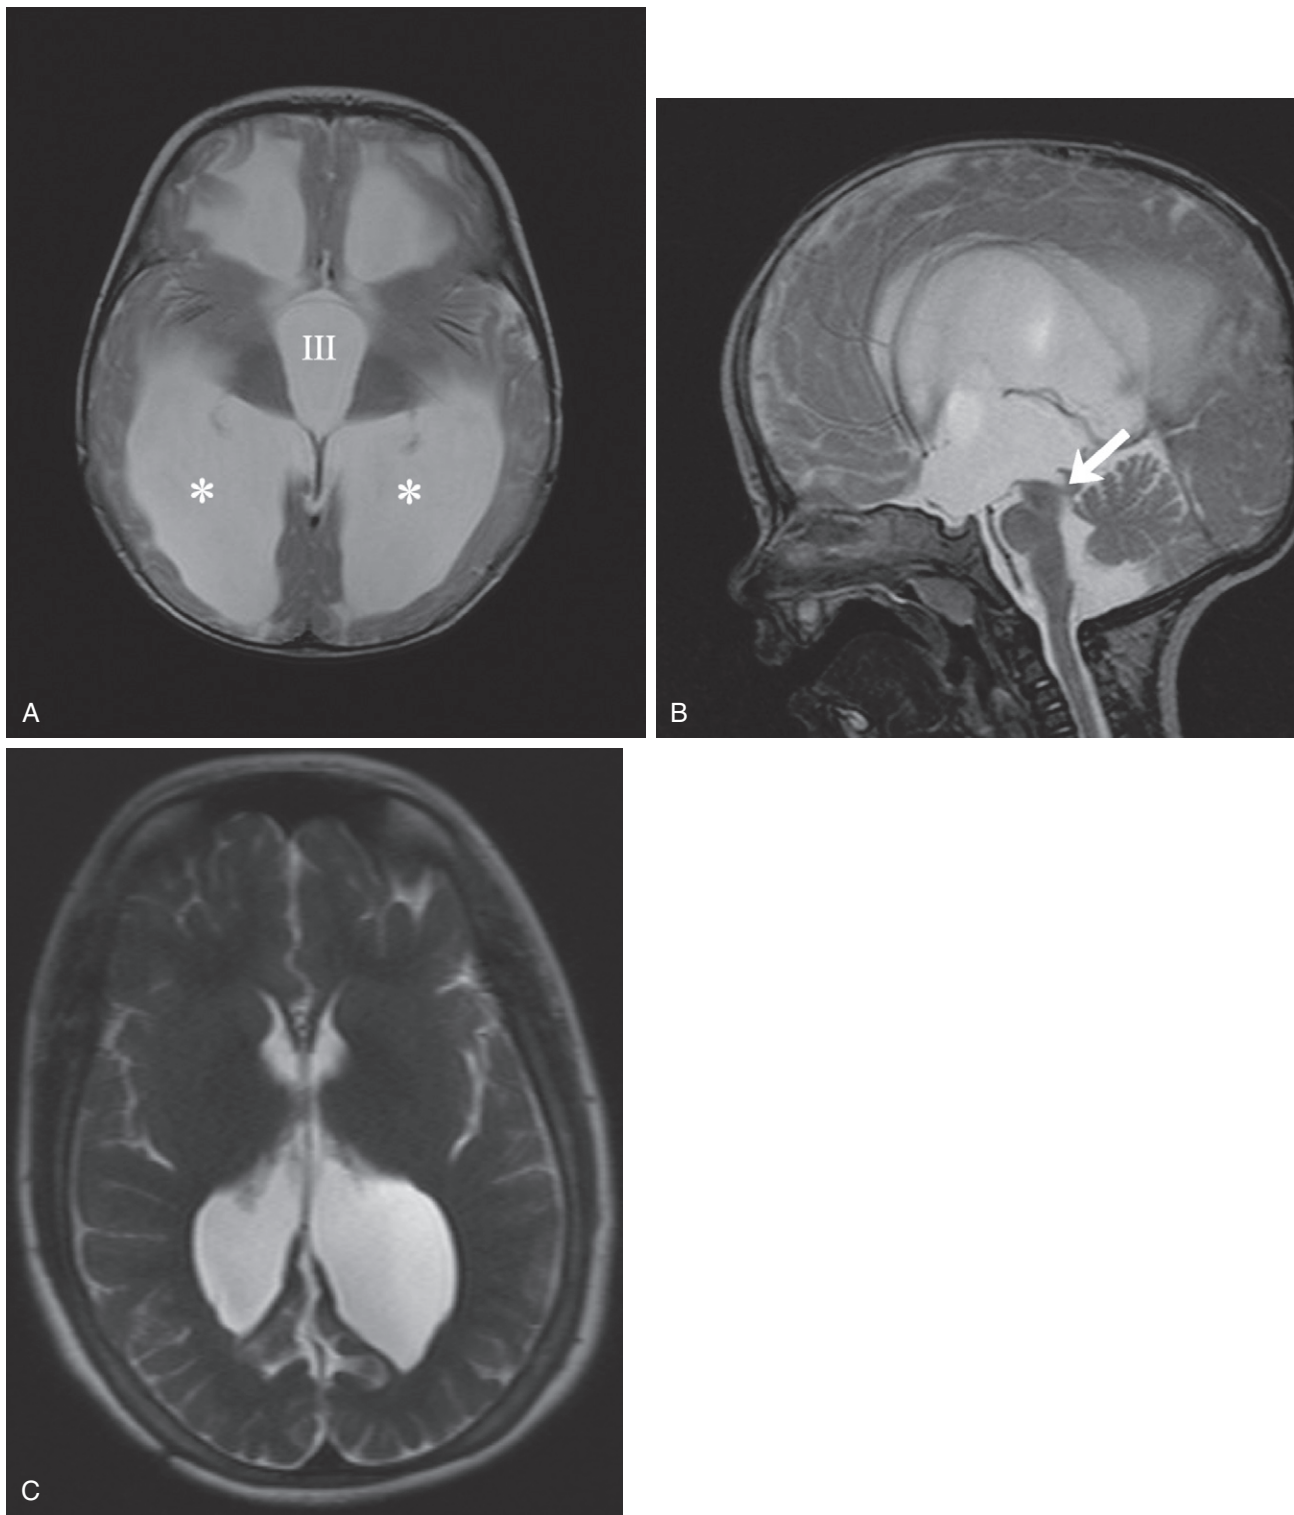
Obstructive hydrocephalus. Axial (A) and midline sagittal (B) T2 MRI shows dilated lateral (*asterisks*) and third (III) ventricles that result from aqueductal obstruction (*arrow*). C, Chiari II malformation with hydrocephalus. Image demonstrates utility of heavily T2-weighted, half-Fourier acquisition, single-shot, turbo spin-echo MRI in evaluation of ventricles. Sequence can be obtained rapidly without the need for sedation; this avoids the radiation associated with repeated CT scans.
